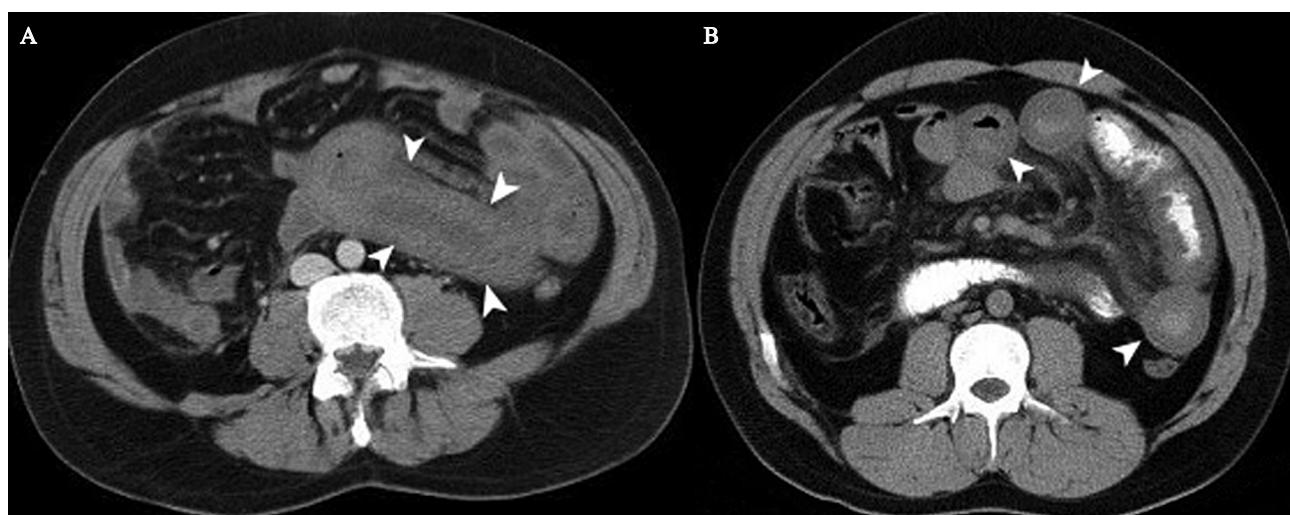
Abdominal CT imaging; (A) a 68-year-old male patient; homogenous and symmetrical wall thickening in the jejunum segment on CT examination. The hyperdense appearance in the wall, which is characteristic of early hematomas, can be clearly identified (arrow heads). (B) A 58-year-old male patient; symmetrical and homogenous wall thickening can be seen in different jejunal segments on CT examination (arrow heads).
